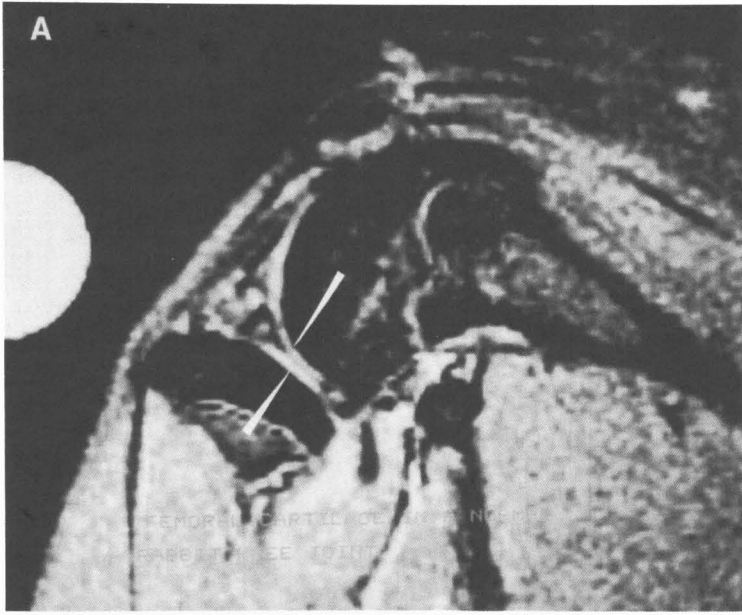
A, Two-dimensional MRI of control femoral and tibial cartilage (arrows) with normal thickness and intensity. B, Two-dimensional MRI of femoral and tibial cartilage (arrows) after 5 days of infusion with IL-1 shows thinning and hypointensity compared with normal control; note location of infusion tube (arrow) in this 0.7-mm section. C, Two-dimensional MRI of femoral and tibial cartilage (arrows) after 12 days of IL-1 infusion shows cartilage degeneration and inflammation; note location of infusion tube (outlined arrow) in this 0.7-mm section.
